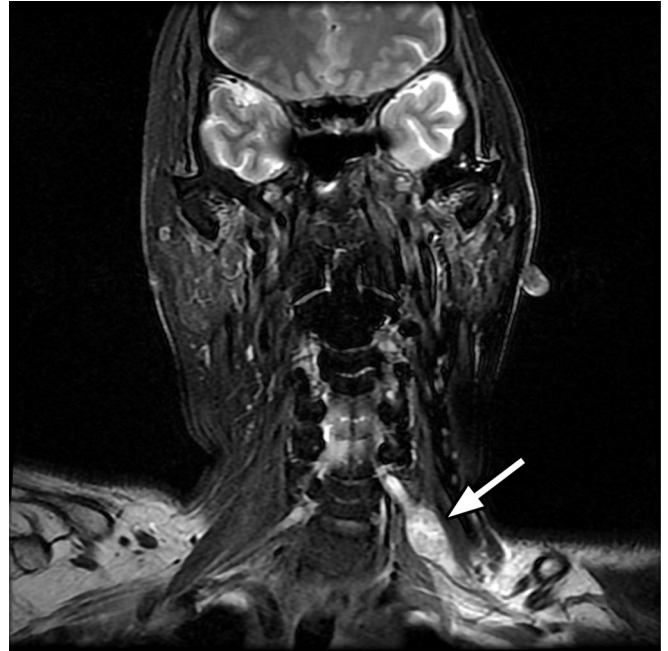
After reexamining the aforementioned follow-up MRI, we noticed a small, well-circumscribed, hyperintense lesion with relatively central hypointensity in the left lower neck region on the T2-weighted image with fat suppression (arrow). In addition, the location of this lesion seemed connecting with the root of left sixth cervical spinal nerve. The image features revealed that the lesion might originate from the spinal nerve, and most frequently, it might be a periphery nerve sheath tumor such as neurilemmoma.
